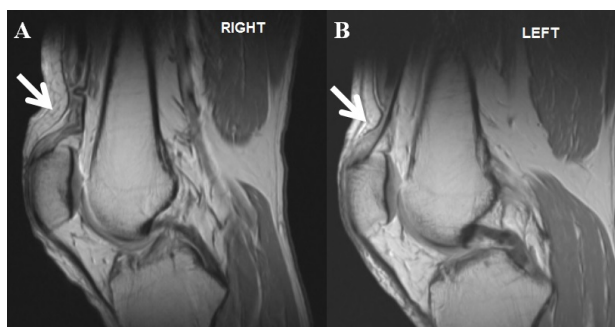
Magnetic resonance images showing the quadriceps rupture in both knees. The right (A) and left (B) knee demonstrated a large rupture of the quadriceps fibers (white arrows), with minimal joint effusion
